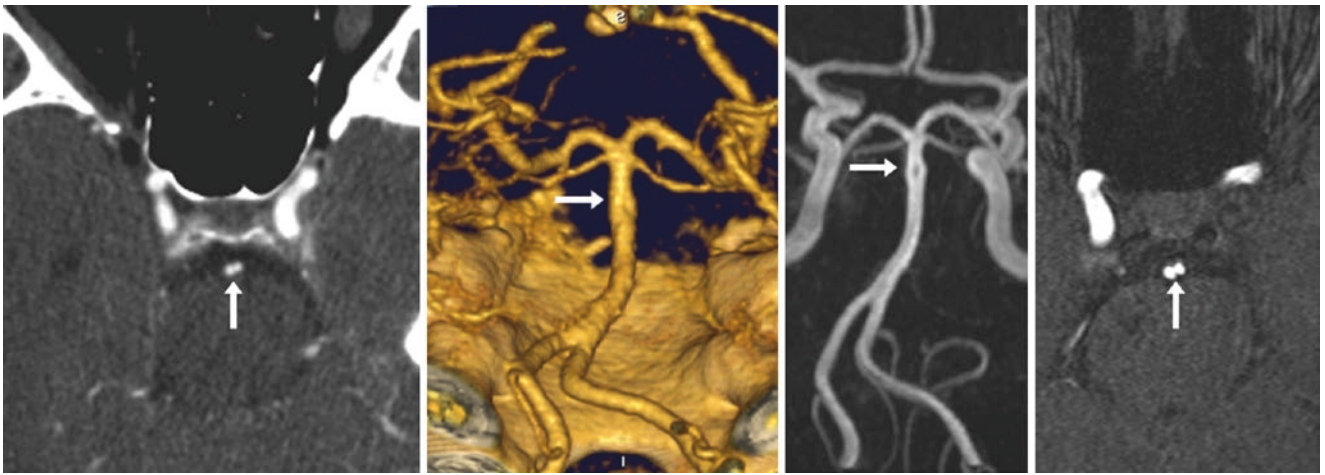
53-year-old with the cleft of a tiny mid-basilar fenestration (*arrows*), questioned on source CTA images (*left*), although not seen on 3D VR images (*posterior view, left middle*). The fenestration was better visualized on a 3DTOF MRA posterior view (*right middle*), and the cleft was clearly seen on axial source images (*right*)
